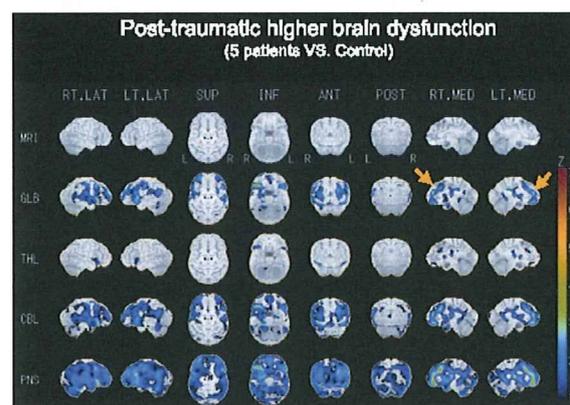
脳外傷後高次脳機能障害例のSPECT画像解析
